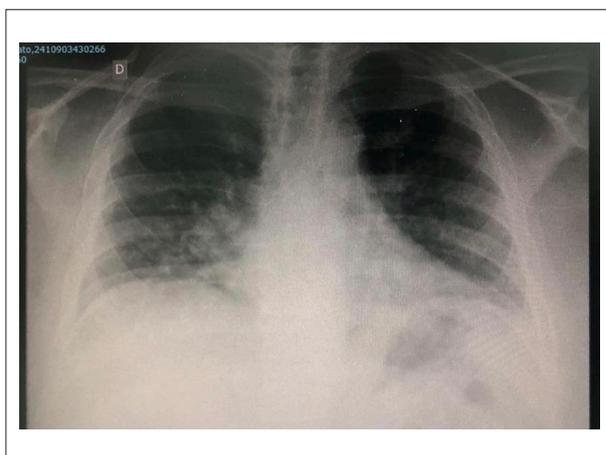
Chest radiography referring to the second appointment.
